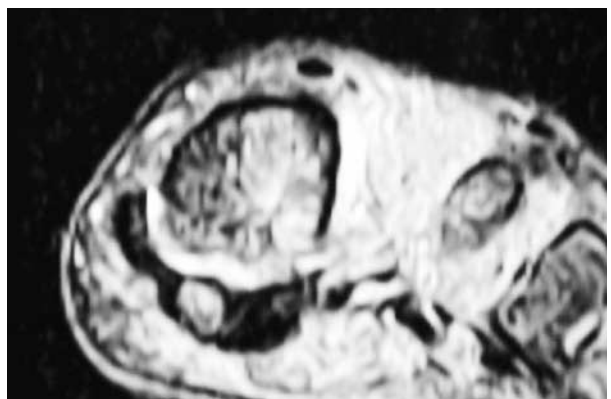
Magnetic resonance image showing a focal area of calcification located at the region of the lateral sesamoid.
